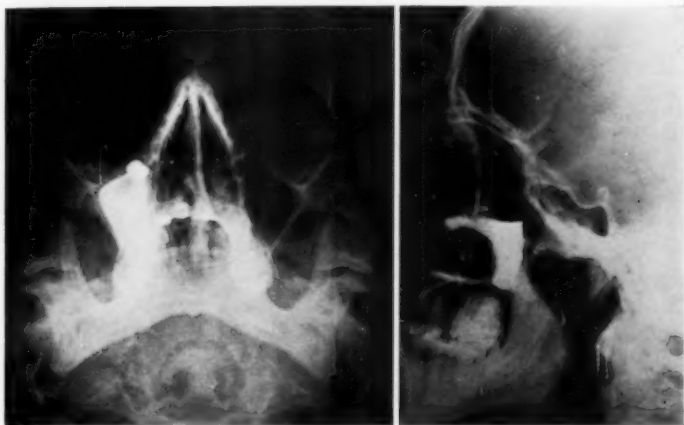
Case III. X-rays, Waters and lateral views, showing large filling defect in right antrum. At operation, this proved to be a cyst.
